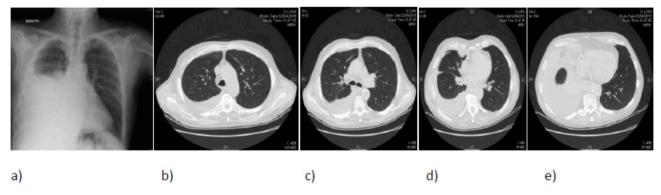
a) Chest Xray; b)-c)-d)-e): Chest CT at different level from apex to the basis of lung.
